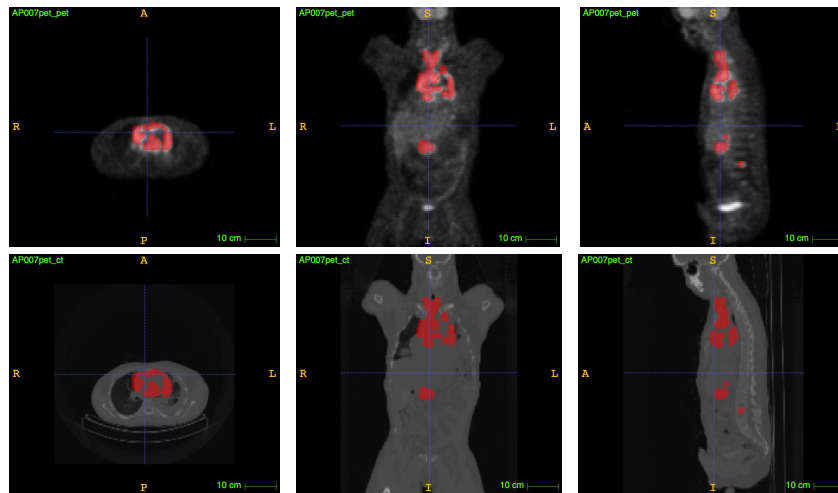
Examples of patient with lymphomas. The first and second rows show, respectively PET and CT, slices of one patient in axial, sagittal and coronal views. The lymphomas are marked in red.
